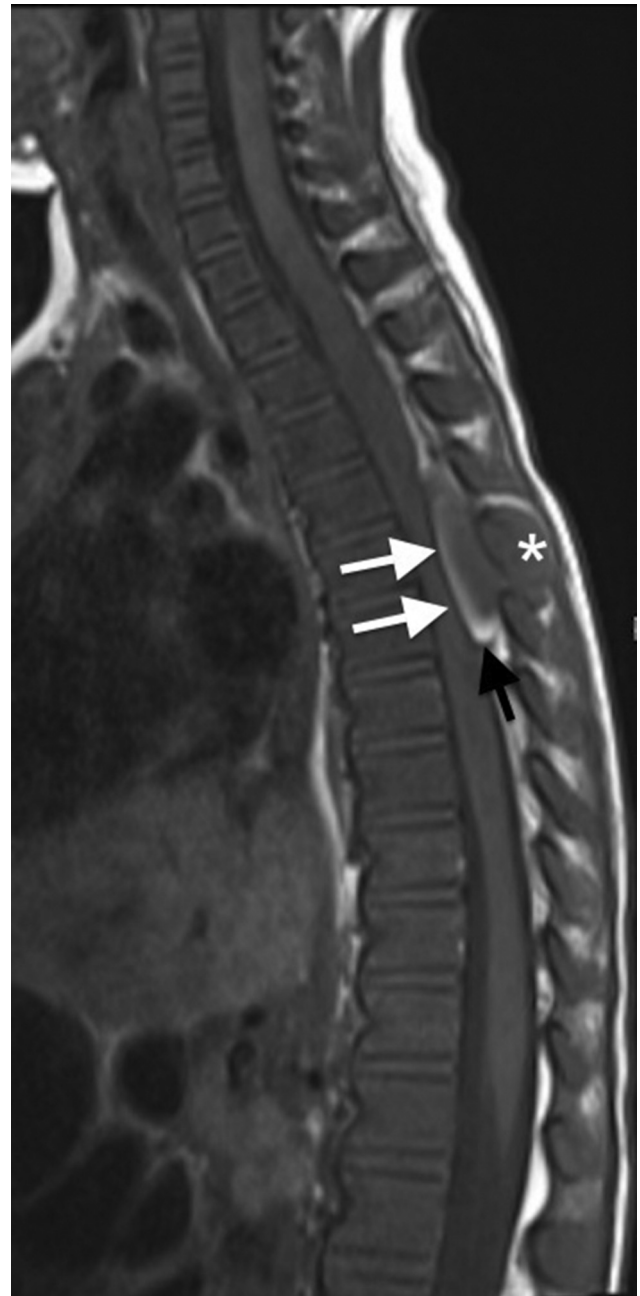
T1-weighted magnetic resonance image revealed an epidural mass at the level of T4–T6 vertebrae (white arrows). The lesion had hyperintense rim considered to be hemorrhage (black arrow). Note the invasion and expansion of spinous process of T5 vertebra (asterisk).
